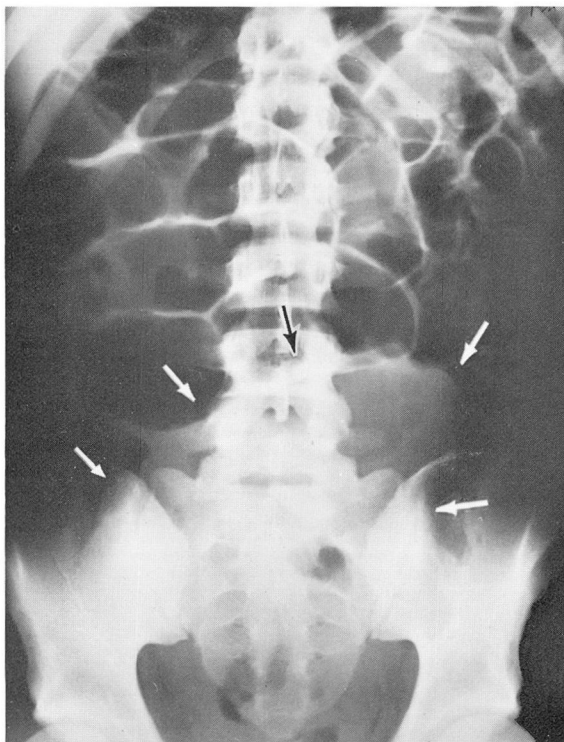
Roentgenogram (plain film) of the abdomen, showing evidence of partial intestinal obstruction and a large pelvic mass.
